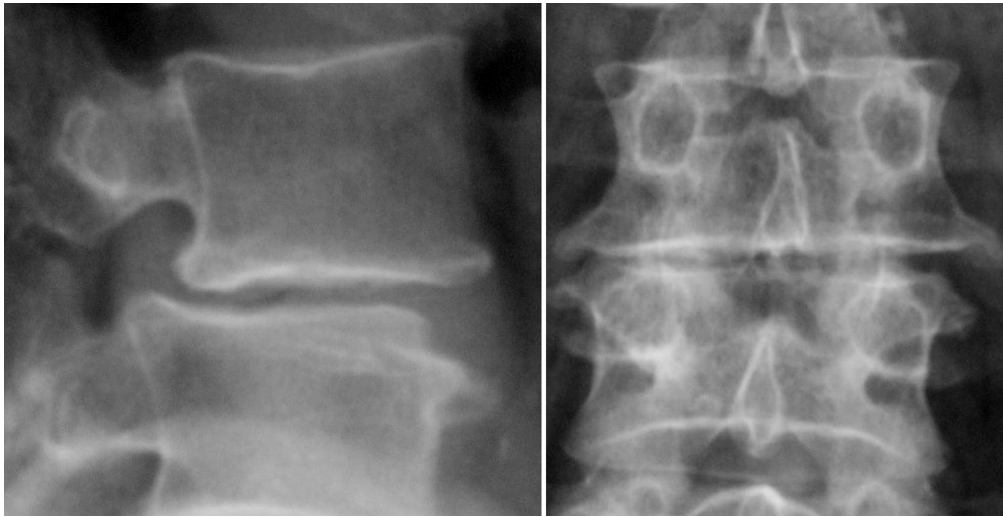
Radiographs demonstrate true lateral (*left*) and anteroposterior (AP) (*right*) images. Note that in the lateral view the end plates can be visualized easily, and the pedicles are superimposed. The AP view demonstrates the spinous processes at each level seen in the midline and the transverse section of each pedicle.
